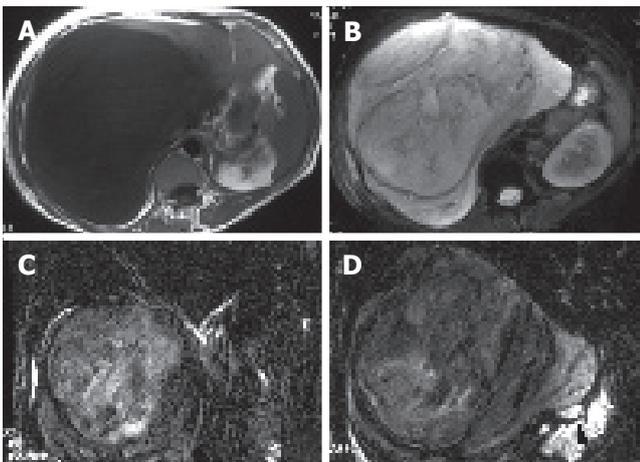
Preoperative MRI images. A: T1-weighted; B: fat-suppressed T2-weighted; B and C: MR Cholangiography. The tumor appeared hypointense on T1-weighted images (A) and hyperintense on fat-suppressed T2-weighted images (B). MR cholangiography revealed that the tumor compressed the right lobe of the liver to the cranial side (C) and gallbladder to the medial-caudal side (arrow head: gallbladder) (D).
